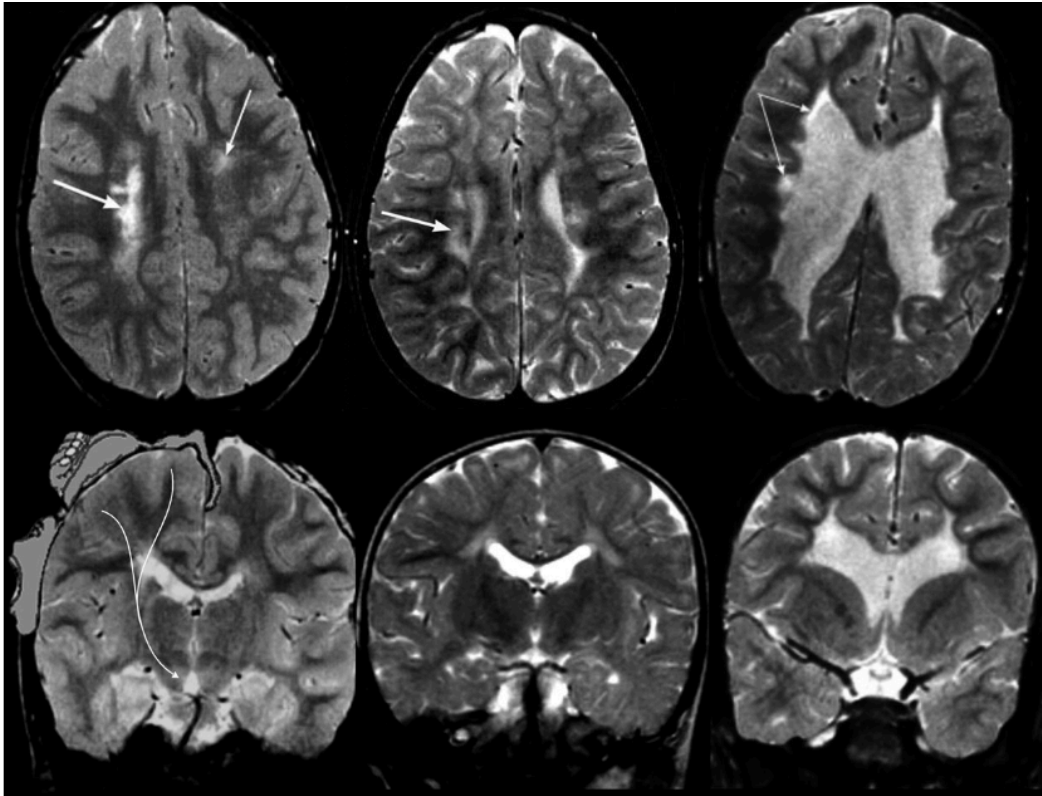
Examples of infant brain MRI scan images showing different types of white matter injury, taken from Himmelmann (7). Left: a mild asymmetrical brain injury involving the right motor tract only. Middle: a mild symmetrical form involving both motor tracts. Right: a severe form, causing bilateral spastic cerebral palsy with severe motor function loss. The upper row shows T2 weighted axial images. The lower row shows T2 weighted coronal images in the domain of the motor tracts (7).
